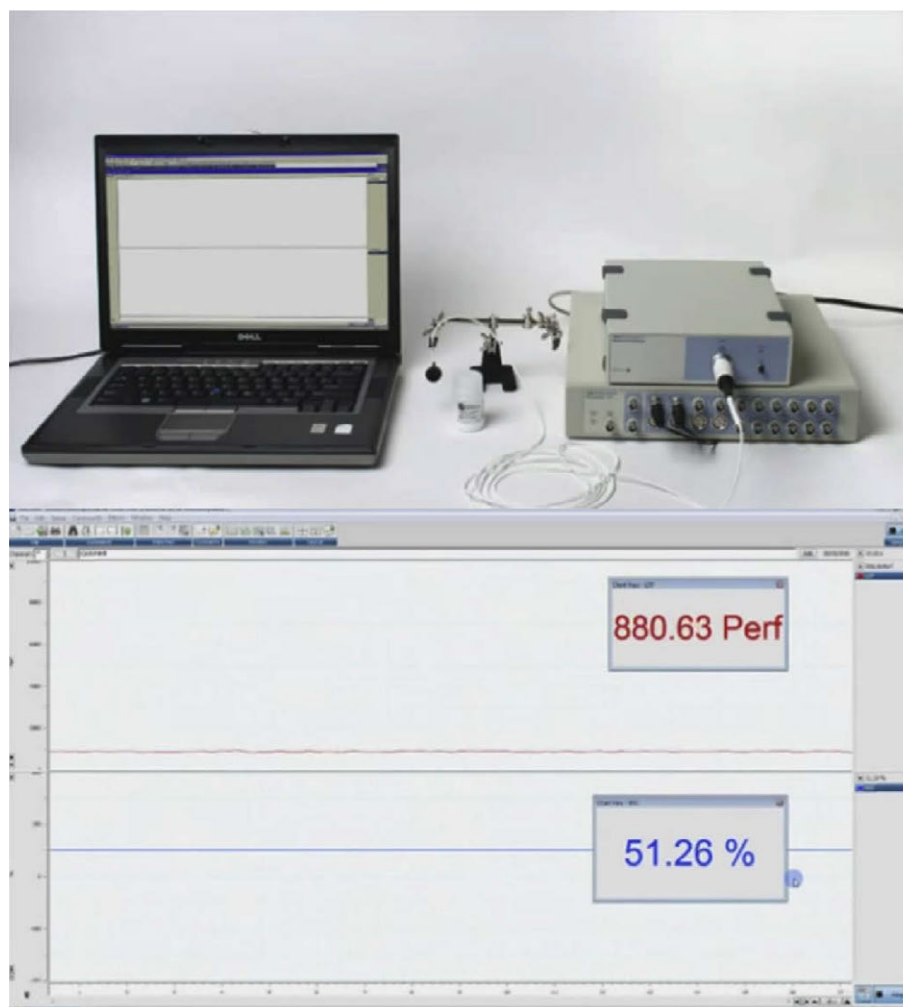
Laser Doppler flow-meter set-up.
